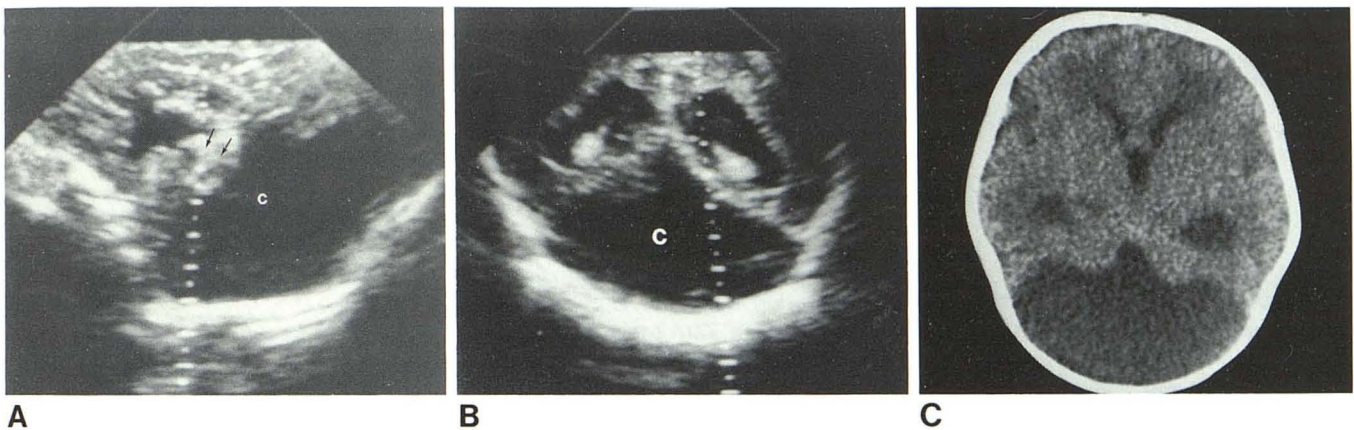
Case 4. A and B, Sagittal midline and coronal sonograms. Large cyst occupies entire posterior fossa (c) with superior displacement and hypoplasia of vermis (arrows). Note dilated ventricles. C, CT scan confirms cystic fourth ventricle and hypoplastic cerebellum.
